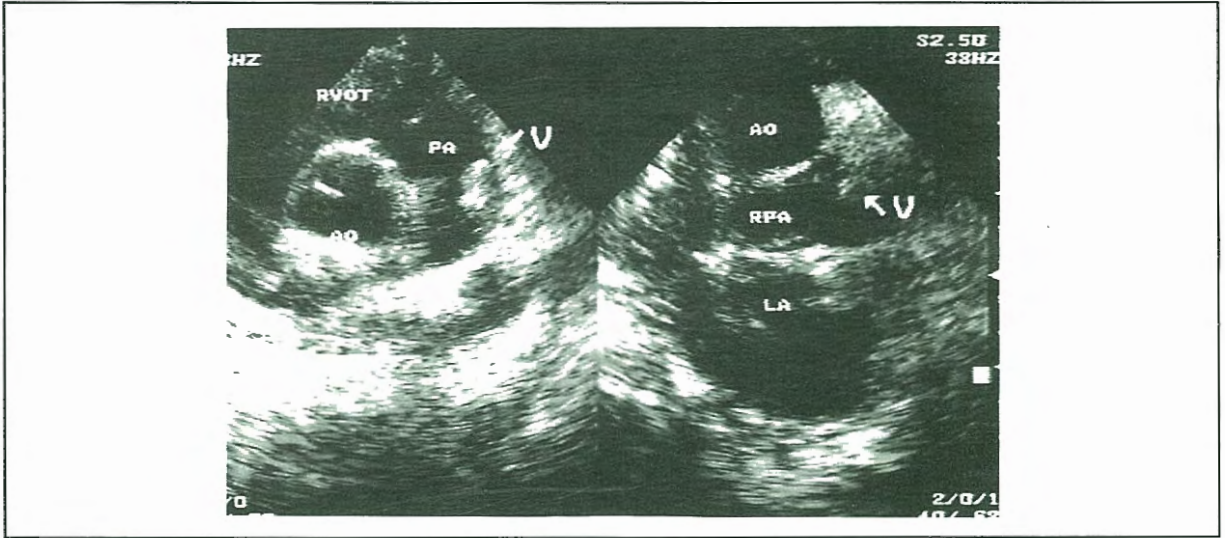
Parasternal short axis and suprasternal short axis view of vegetation in pulmonary in a child with patent ductus arteriosus. RVOT=Right ventricular outflow tract, Ao = Aorta, PA = pulmonary artery, V = Vegetation, RPA = Right pulmonary artery, LA, left atrium.
